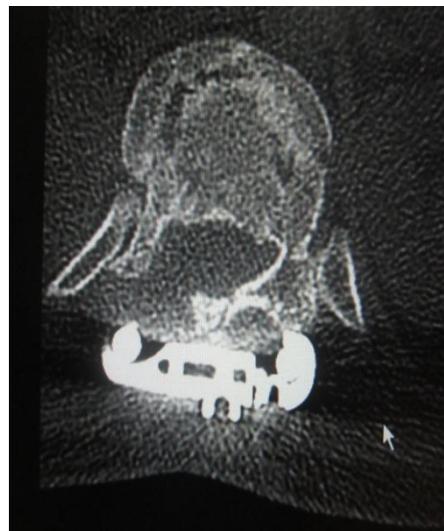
Postoperative CT scan Interpedicular distance measurement
